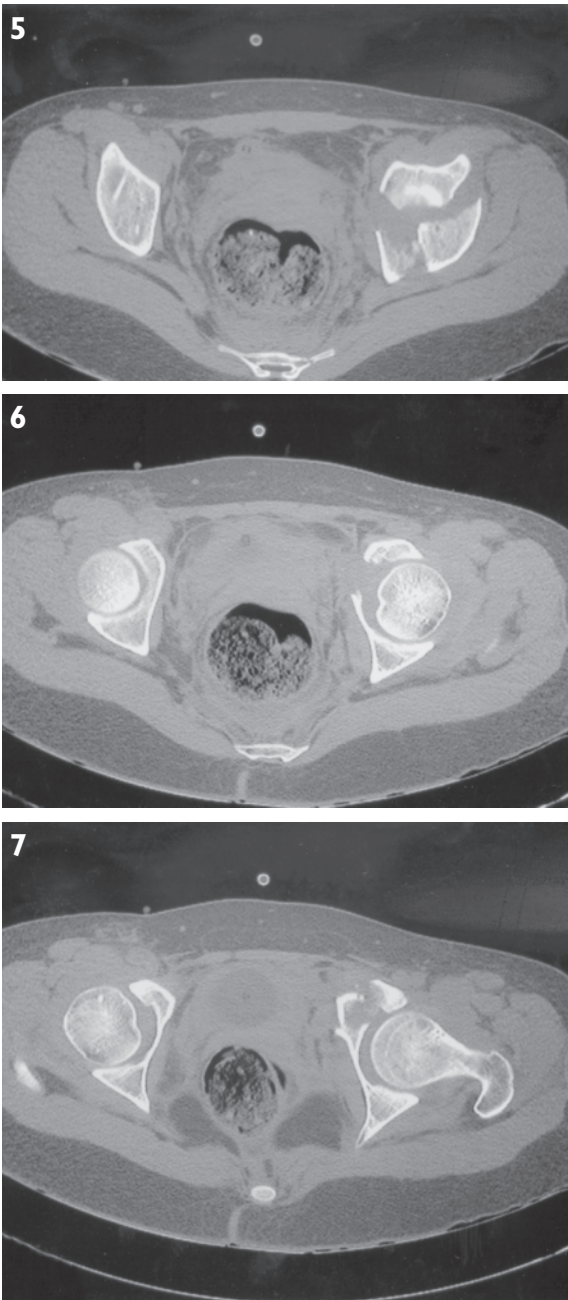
Computed Tomograms of this complex fracture shows a double column fracture.
